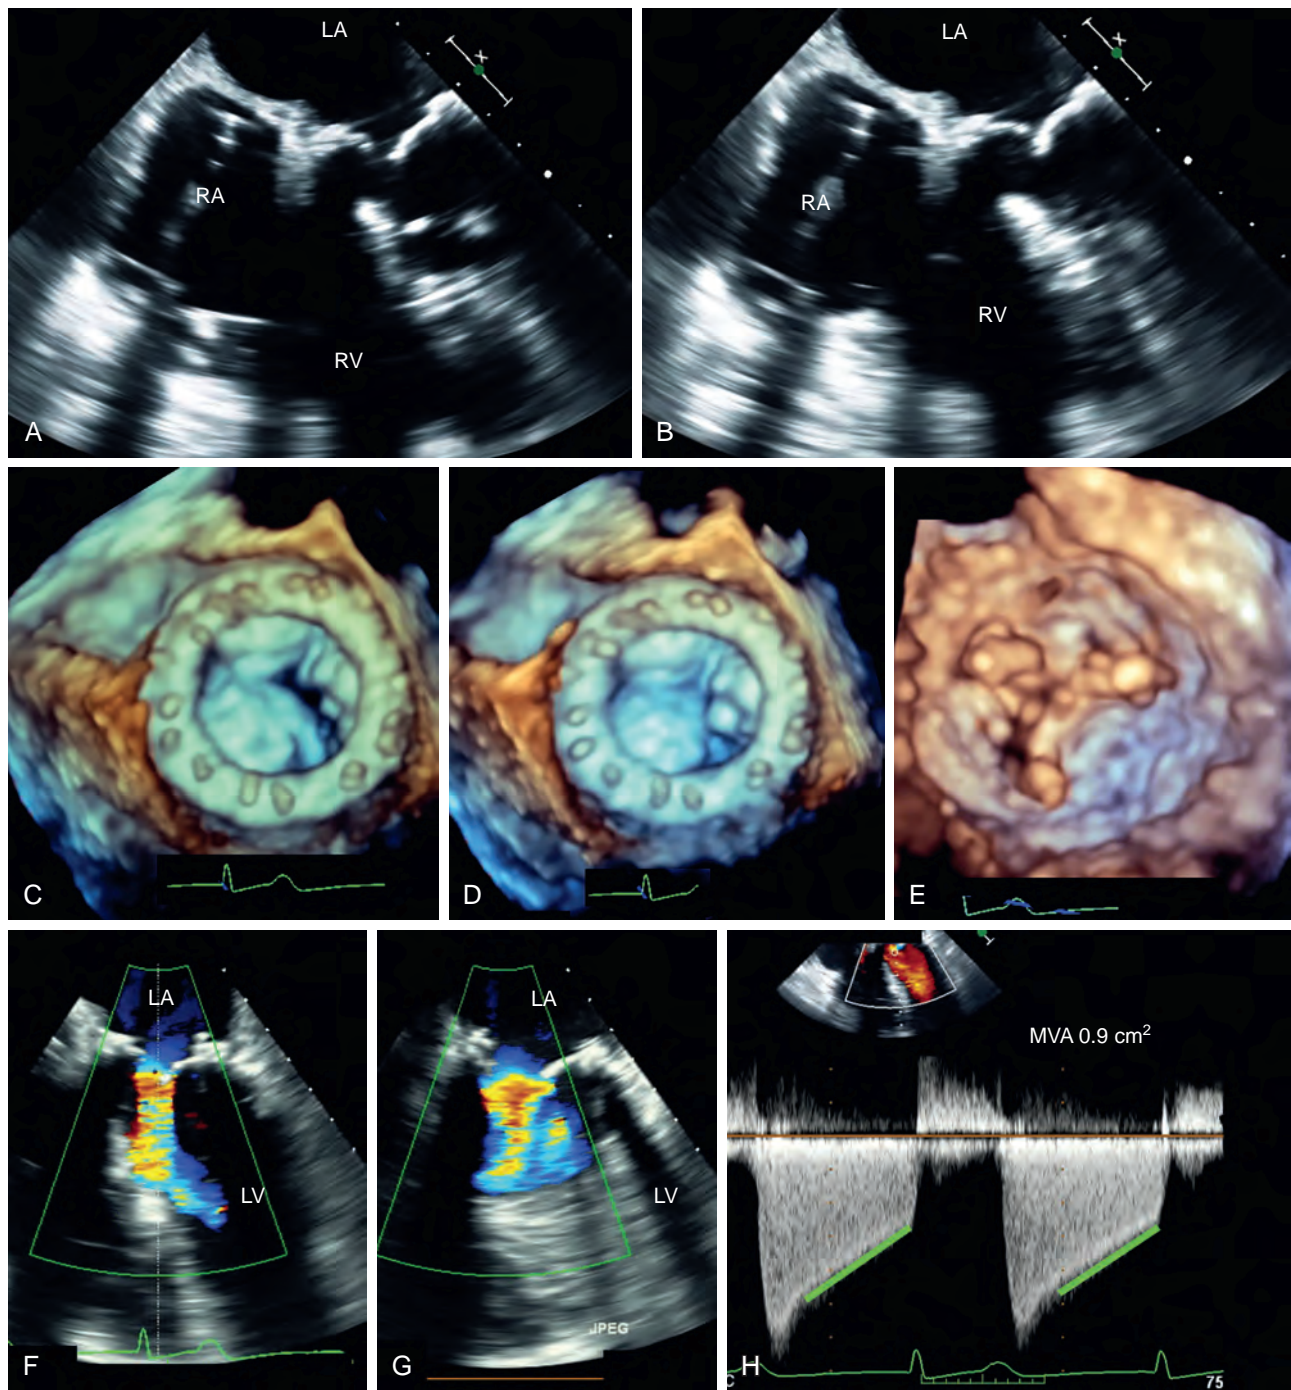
After bioprosthetic mitral valve replacement: degeneration/thickening/restriction. These images demonstrate a complication of bioprosthetic valves in that the leaflets, likely due to inflammation, are thickened, less compliant, and less mobile. This case demonstrates significant mitral stenosis. (A) and (B) Two-dimensional images show echo-bright thickened and immobile prosthetic leaflets during both diastole (left) and systole (right). (C) Three-dimensional image showing a very small opening in diastole from the left atrial perspective. (D) Valve in systole. (E) Three-dimensional image showing a very small opening in diastole from ventricular perspective. (F) and (G) Turbulent forward flow during diastole compared with stenosis and confirmed by (H) the continuous-wave Doppler profile. LA, Left atrium; LV, left ventricle; MVA, mitral valve area; RA, right atrium; RV, right ventricle.
